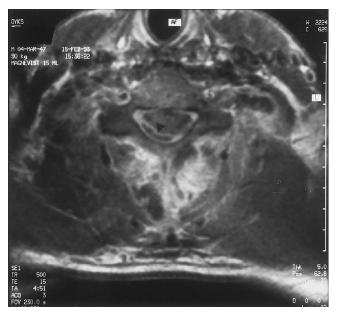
MRI of the neck showing an epidural abscess (*arrow-head*) at the C5 vertebral level in a 44-year-old male patient with deep-neck infection.
